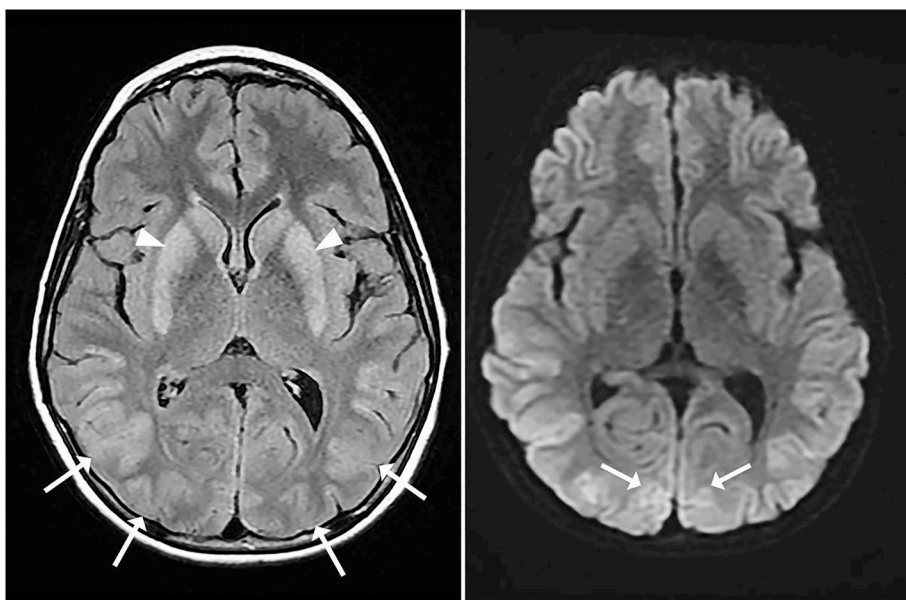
Magnetic resonance imaging. Fluid attenuated inversion recovery (FLAIR) sequence (left panel) demonstrates hyperintense signal throughout the basal ganglia (arrowheads) and cortex, particularly posteriorly (arrows). Diffusion-weighted imaging (DWI) (right panel) shows restricted diffusion with hyperintense signal in multiple cortical areas, including the temporal-occipital regions and calcarine fissures (arrows).
